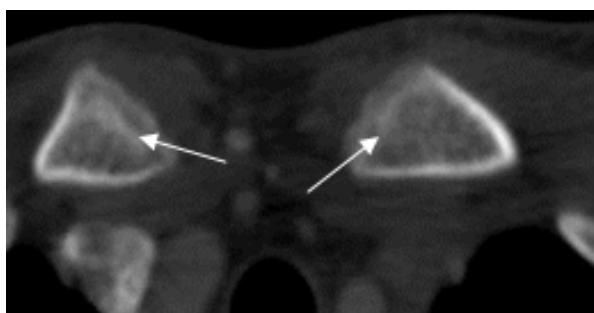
CT image of medial clavicles of a 13 year old male shows sclerotic band associated with growth (white arrows) creating an appearance similar to the physeal scars seen in stage 4a
